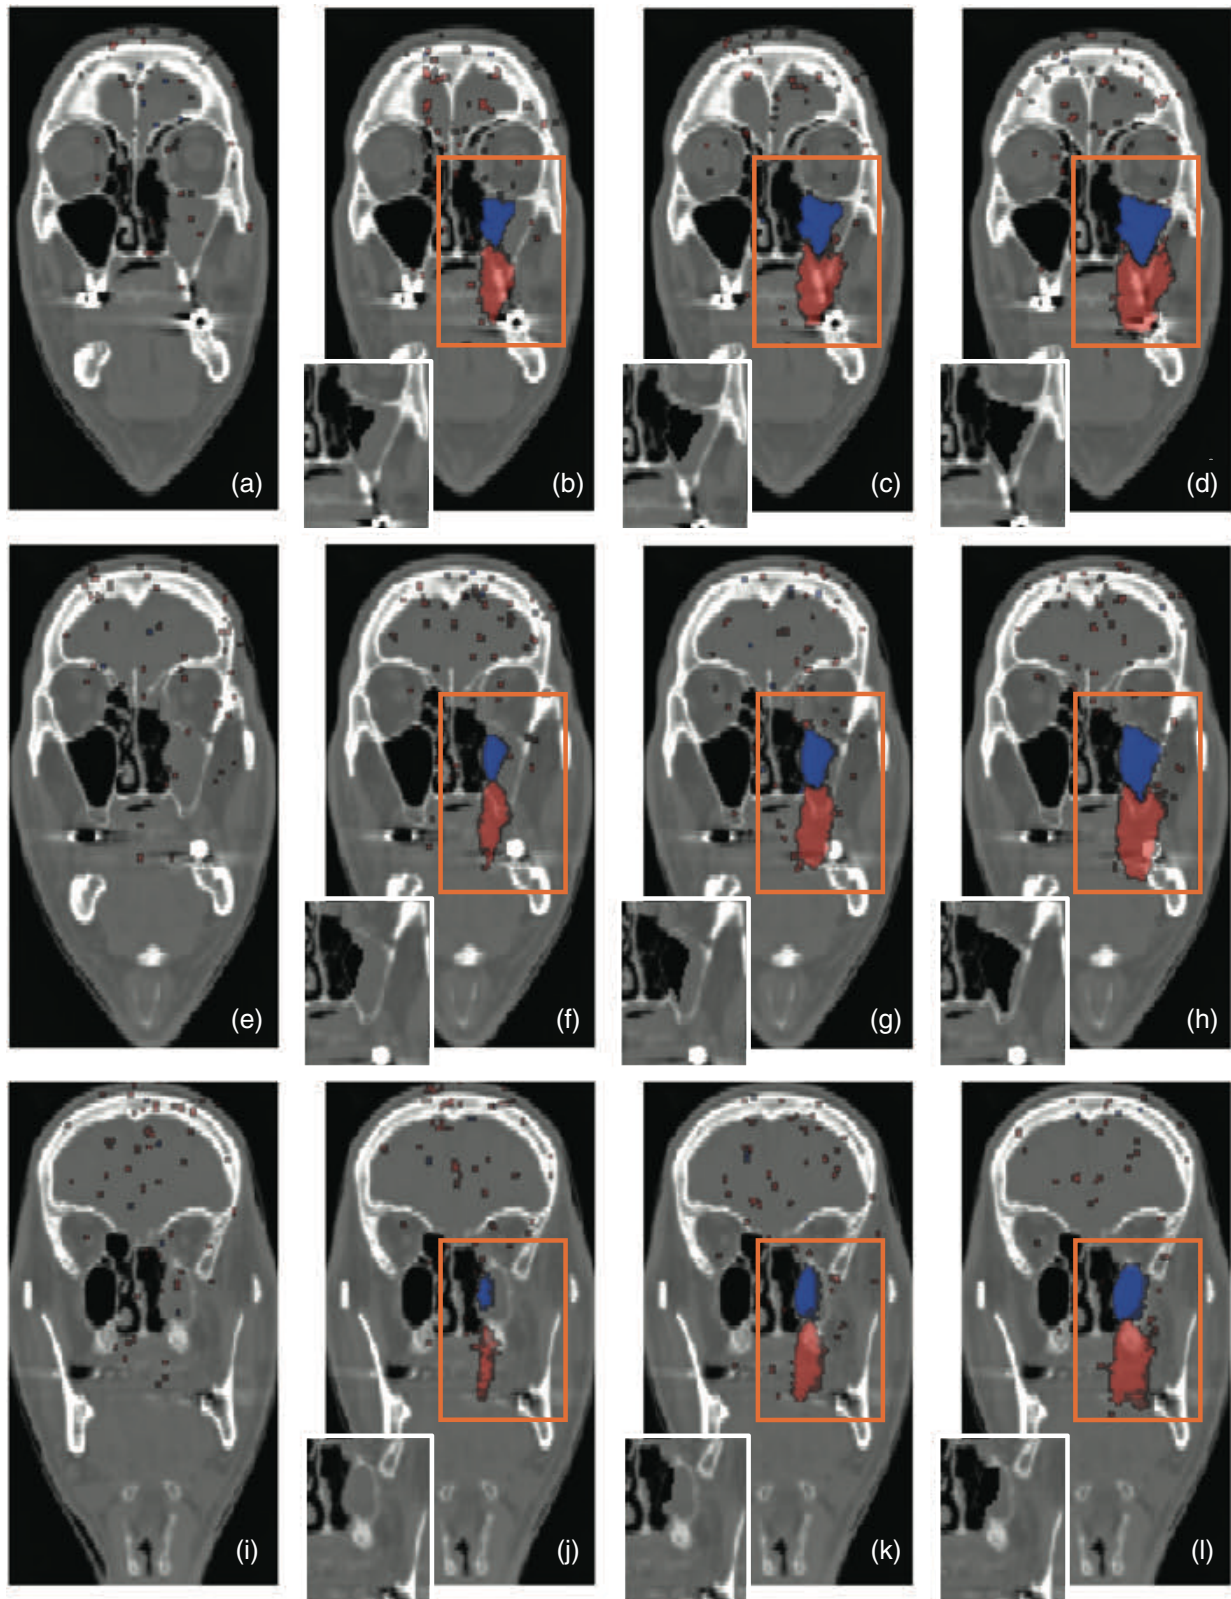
p -value maps resulting from the IPM analysis, for cavity tissue volume reductions of 0.0 mL (a, e, i), 3.8 mL (b, f, j), 7.3 mL (c, g, k), and 13.1 mL (d, h, l). The upper, medium, and lower four plots correspond to a different CT slice. The small insets in the slices show the region in the modified CT that corresponds to the observed p -value map
